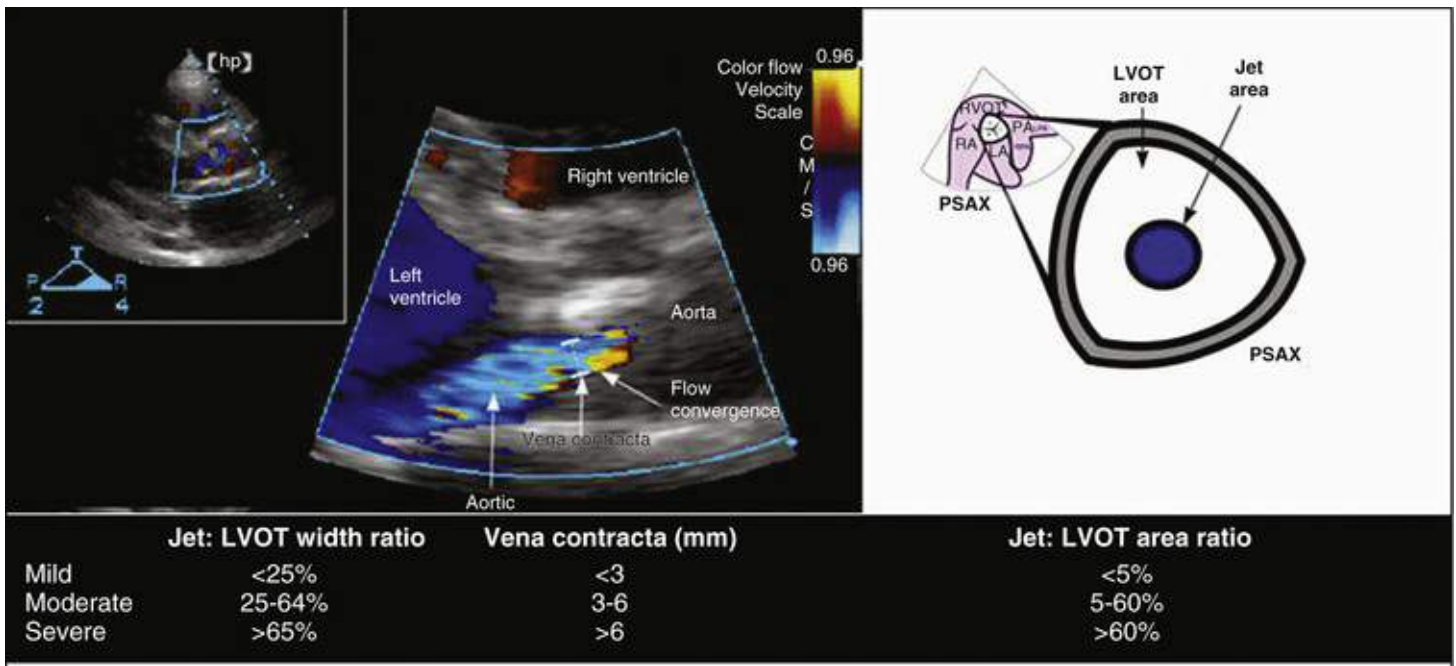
Aortic regurgitation (AR) grading by semiquantitative parameters. Top panel, Color Doppler zoomed in on the parasternal long axis (*left*) view of the aortic valve showing the AR jet. Parameters that correlate roughly with grades of AR are shown chart below each measurement. The jet height and left ventricular outflow tract (LVOT) height are measured directly on the images. The jet area can be traced by planimetry. LVOT area is calculated as $0.785 \times (\text{LVOT diameter}/2)^2$. Bottom: Left panels, CW Doppler of the jet in apical five-chamber view, showing that the density of the CW jet in diastole, relative to the forward-flow envelope, correlates roughly with the severity of AR. Right panel, PW Doppler with the pulse sample volume placed in the descending thoracic aorta near the origin of the left subclavian artery, showing that there is diastolic flow reversal suggestive of at least moderate AR. If diastolic flow reversal is seen even more distally, in the abdominal aorta, the AR is likely severe.
